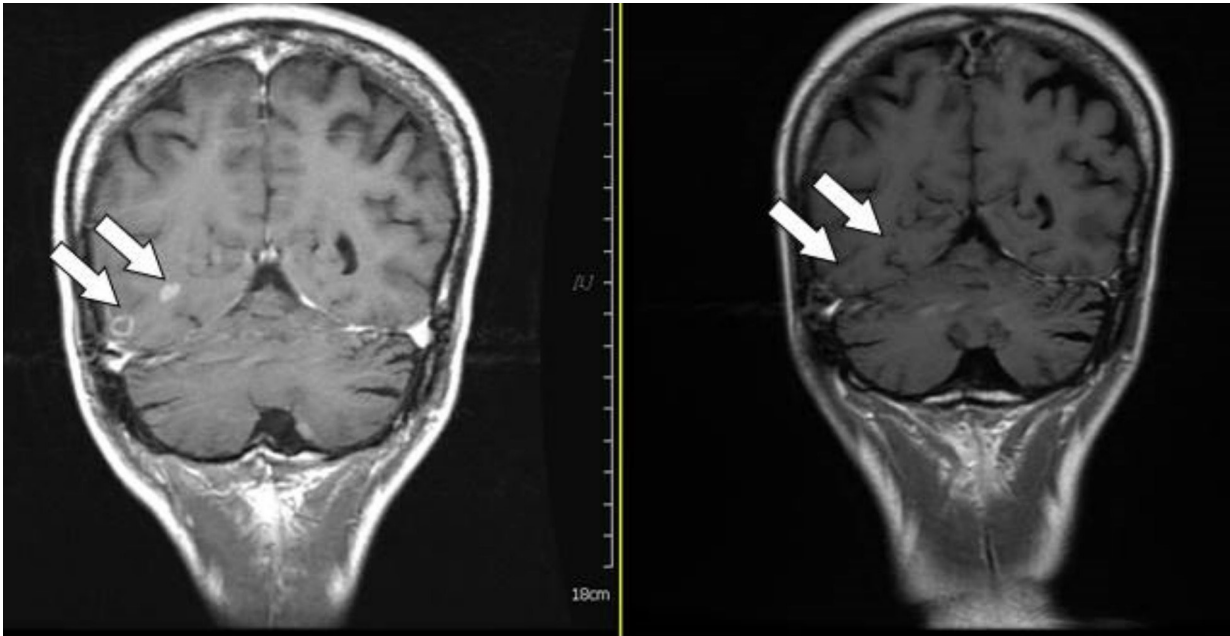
Brain MRI showed brain metastasis status post-WBRT that responded well 6 months later, as shown by the arrow.
